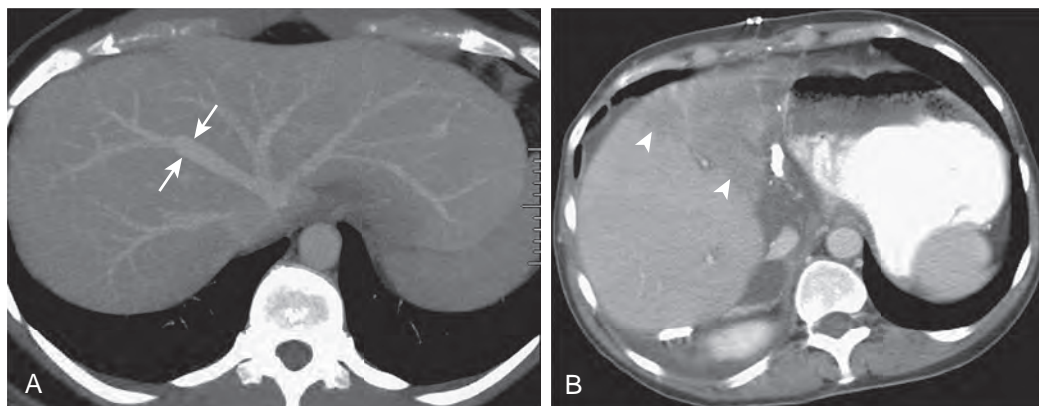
Preoperative evaluation of the potential living liver donor. A. Thick-slab axial maximum intensity projection CT image shows drainage of segment VIII by a prominent early branch of the middle hepatic vein (arrows). B. Enhanced CT shows segmental hepatic venous congestion of the transplanted liver (arrowheads).
